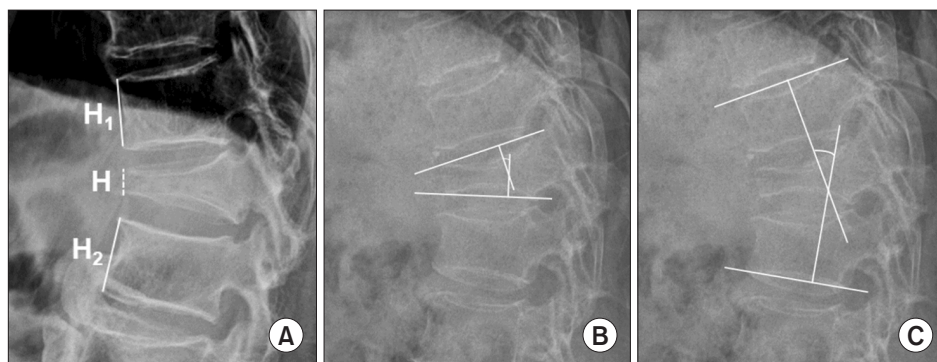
Measurements of radiological parameters using a standing neutral lateral plain radiograph. (A) Anterior vertebral body compression percentage (AVCP). $AVCP = 100 \times [(H1 + H2) / 2 - H] / (H1 + H2) / 2$. H: anterior vertebral body height (AVH) of the fractured vertebra, H1: AVH of the above vertebra, H2: AVH of the below vertebra. (B) Vertebral kyphotic angle. (C) Local Cobb angle.
